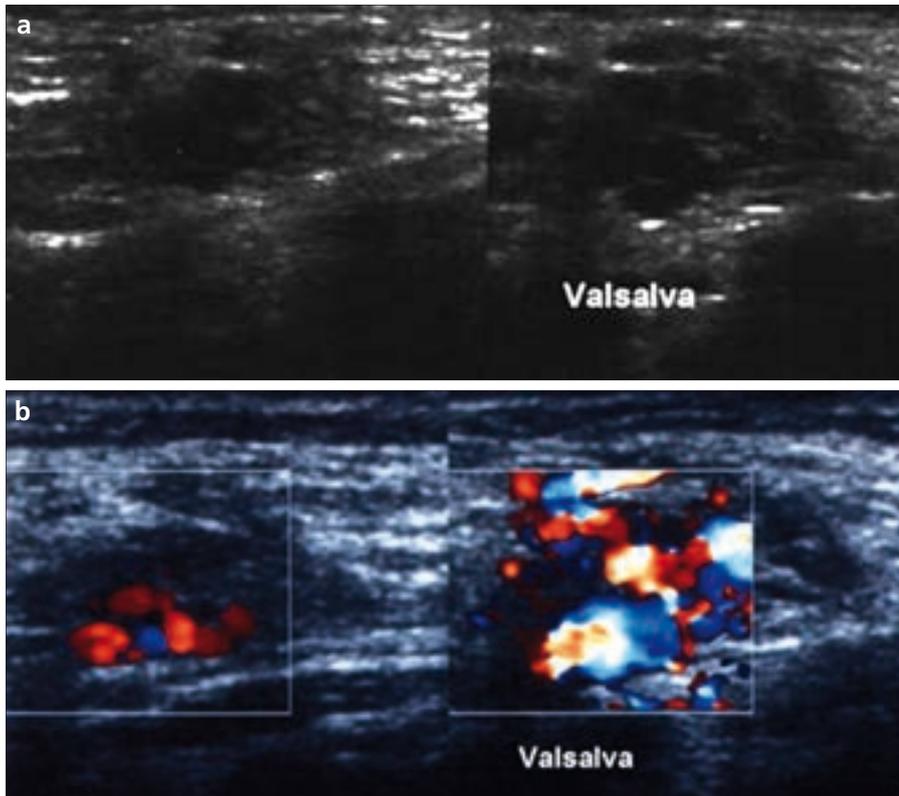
a, b. Gray-scale (a) and color Doppler imaging (b) show a mass in the right groin composed of multiple echo-free serpentine tubular channels that filled with color on Doppler imaging. During Valsalva maneuver, the lesion shows dilatation and marked flow augmentation.
